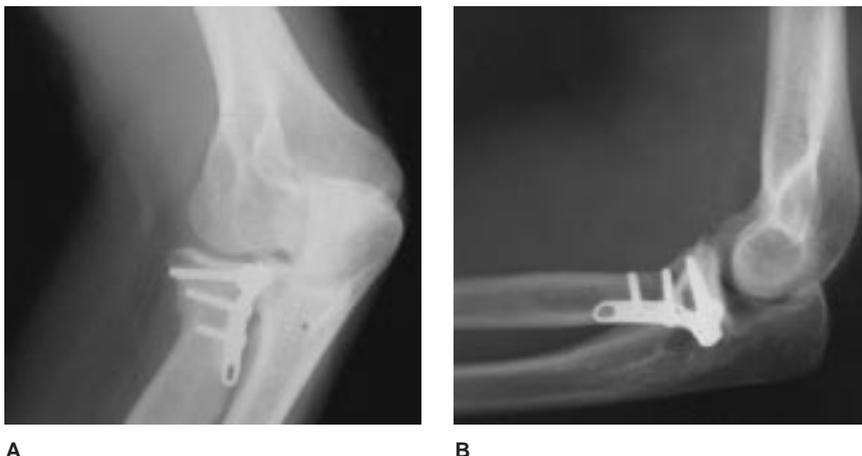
Anteroposterior (A) and lateral (B) radiographs of an elbow in which a minifragment plate has been used to treat an unstable fracture-dislocation. Plates must be placed in the “safe zone” of the radial head to avoid a mechanical block to forearm rotation.
